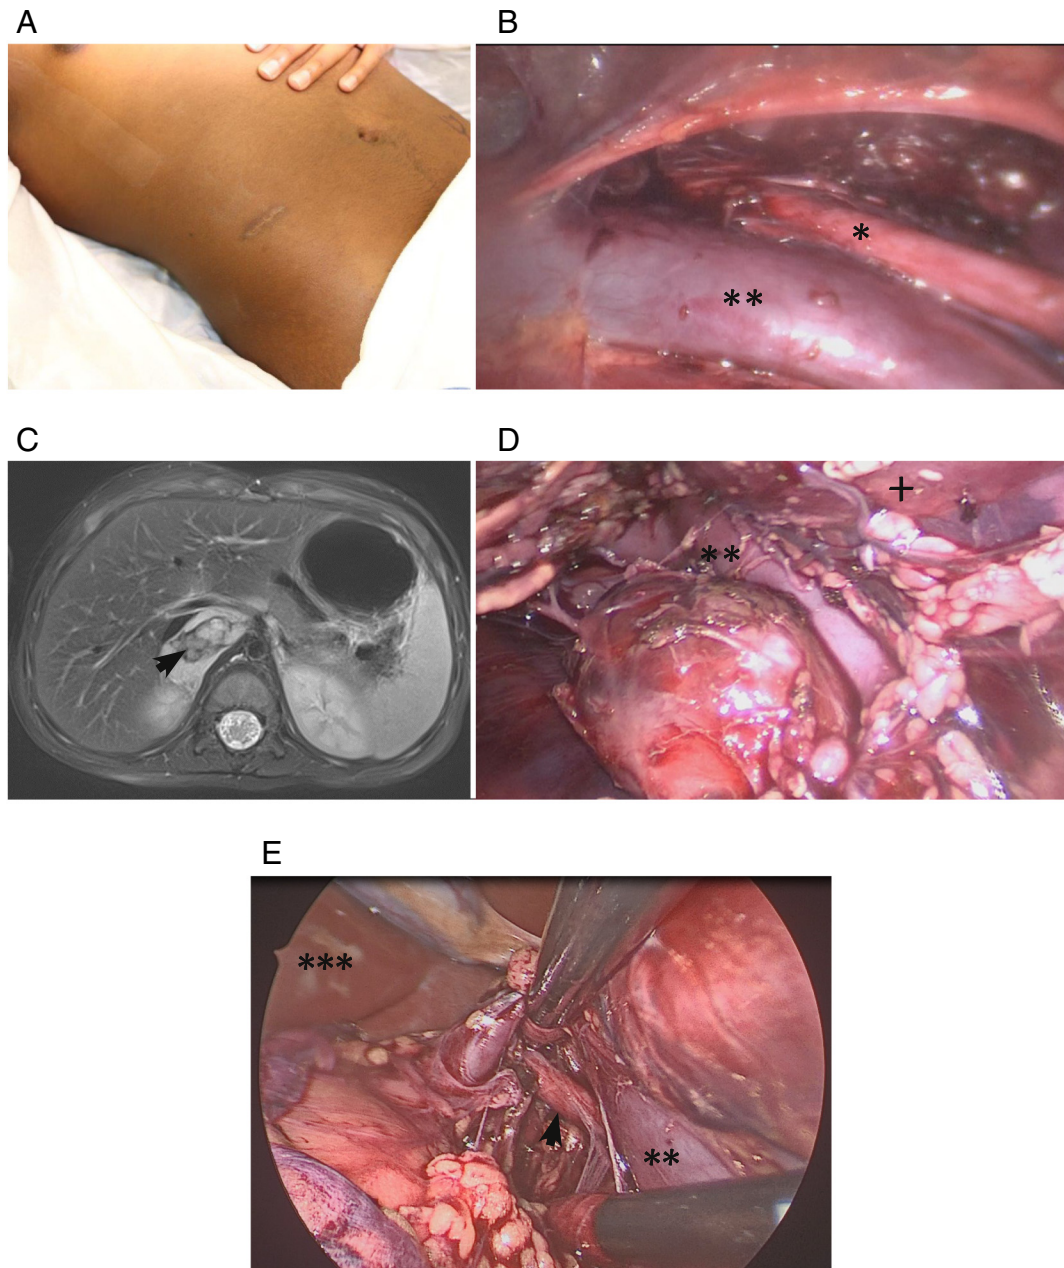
Adequate visualization of retroperitoneal structures through a single 2- to 2.5-cm flank incision (A) on a patient lying in a supine position. (B) Retroperitoneoscopic view of the inferior vena cava (IVC) () and aorta (*). (C) Computed tomography scan revealing the right adrenal mass (arrow), with its retroperitoneoscopic view (D) revealing the adrenal mass and suprarenal retrohepatic IVC () without the need for a liver (+) retractor. (E) A standard transperitoneal laparoscopic approach for a lymph node dissection revealing the IVC () and renal artery (arrow), with the liver (*) being retracted in background.
